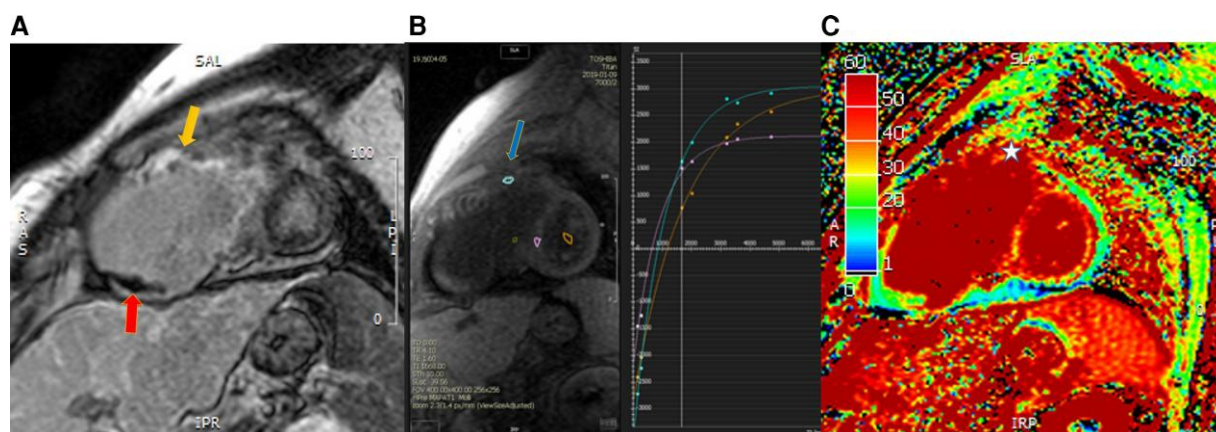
Cardiac magnetic resonance imaging with tissue characterization. (A) The late gadolinium enhancement sequence showed diffuse and heterogeneous subendocardial fibrosis in the right ventricle apex (downward arrow) and thrombus in the right atrium (upward arrow). (B) The native T_1 value in the right ventricle was increased (1287 ms; downward arrow). (C) The extracellular volume was 38% (star).
